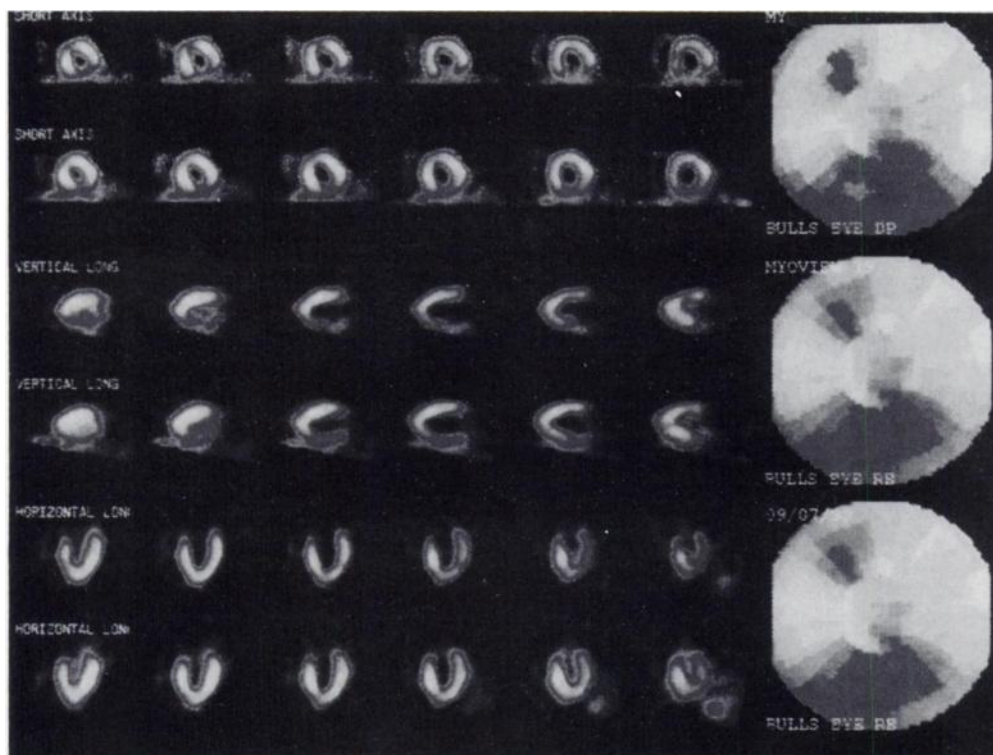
Technetium-99m-tetrofosmin SPECT after dipyridamole administration in a 47-yr-old man demonstrated moderate perfusion defects of the inferior and posterior walls, which were reversible in the rest study. Coronary arteriography demonstrated right coronary artery occlusion with collaterals filling the distal artery.
